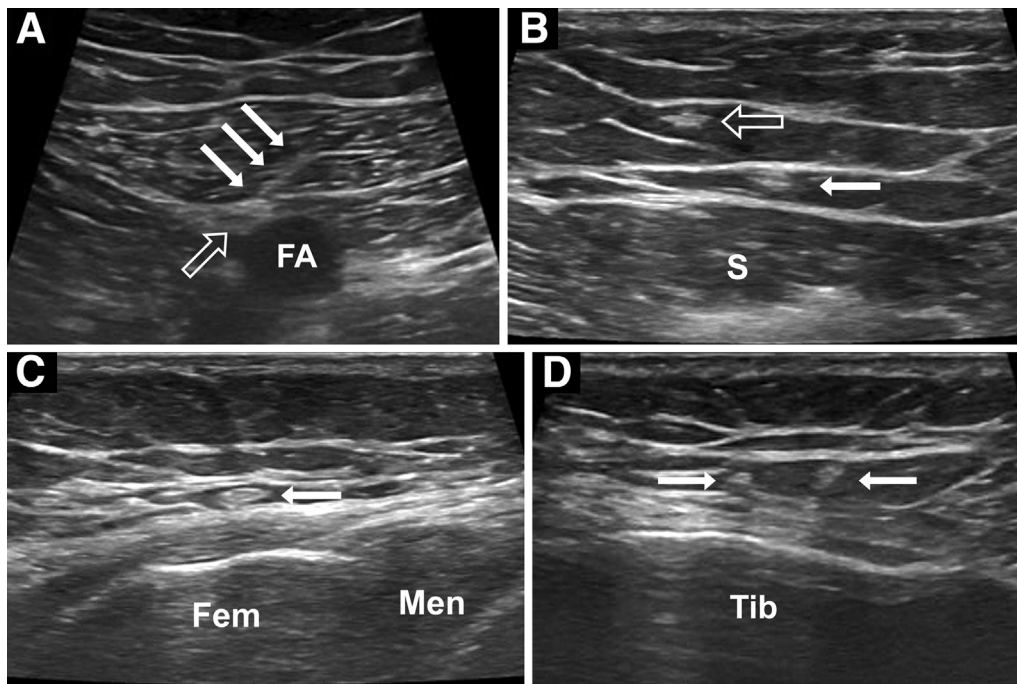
Transverse sonographic images of the infrapatellar branch of the saphenous nerve obtained (1) at the origin from the saphenous nerve (A), (2) at the fat pad superficial to the sartorius muscle (B), (3) at the medial tibiofemoral joint line (C), and (4) in the infrapatellar region (D). The images were obtained from a volunteer's left side (A) or from a volunteer's right side (B-D). The numbers 1 through 4 correspond to the anatomic locations shown in Figure 2. The filled arrows indicate the infrapatellar branch of the saphenous nerve, and the open arrows indicate the saphenous nerve (1) or medial femoral cutaneous nerve (2). (FA, femoral artery; Fem, femur; Men, meniscus; S, sartorius muscle.)
